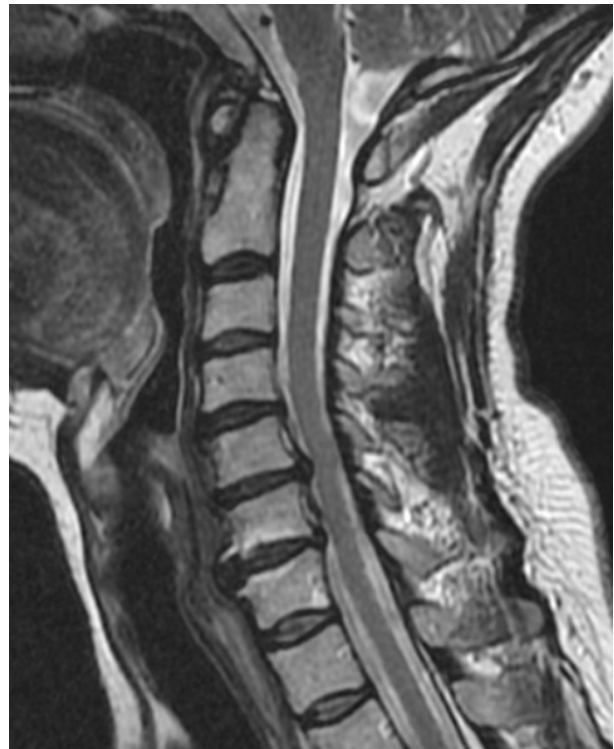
Sagittal section of the cervical spine in T2 MRI. Herniated disc C5-C6. Disc protrusion C6-C7.
